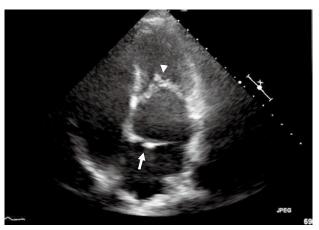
Echocardiography findings. Transthoracic echocardiogram (apical 4-chanber view) shows a membranous structure in the left atrium (arrow). The mitral valve cusps are thickening (arrowhead).
